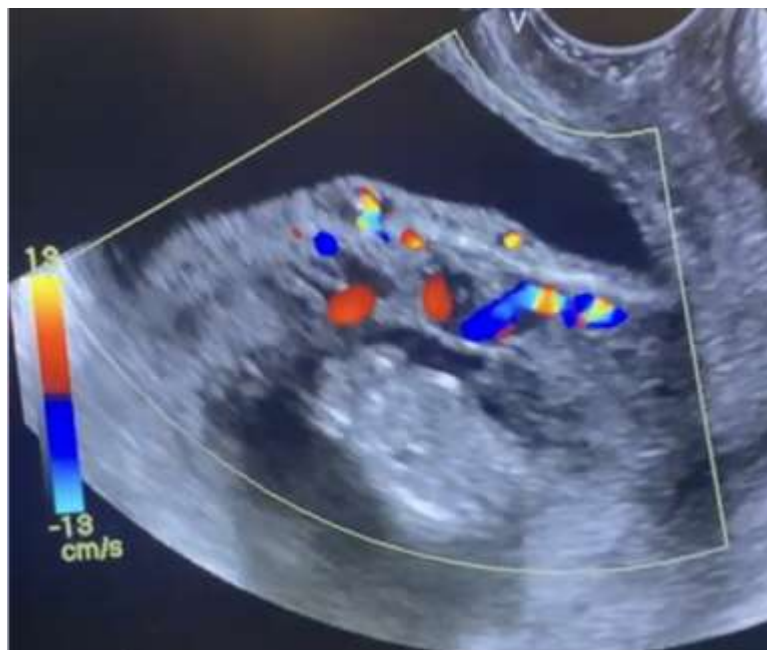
US examination showing of turbulent flow in the color Doppler.
